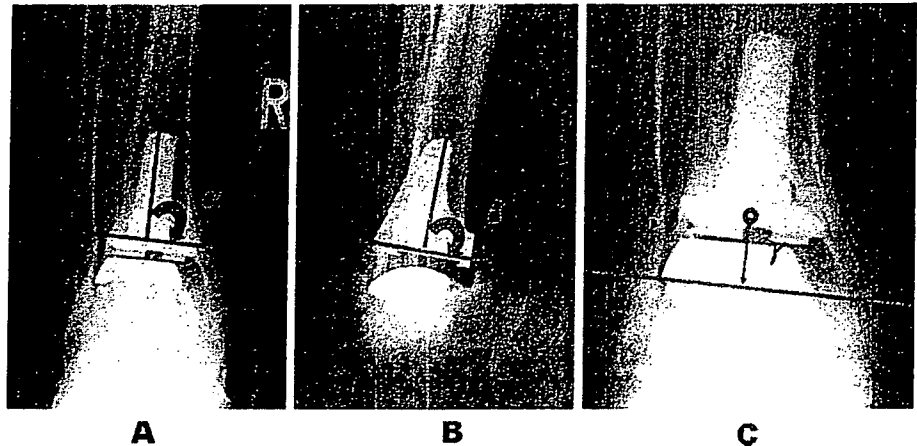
Radiographic evaluation of placement and subsidence of the tibial component. (A) Alpha angle. (B) Beta angle. (C) Gamma length.
